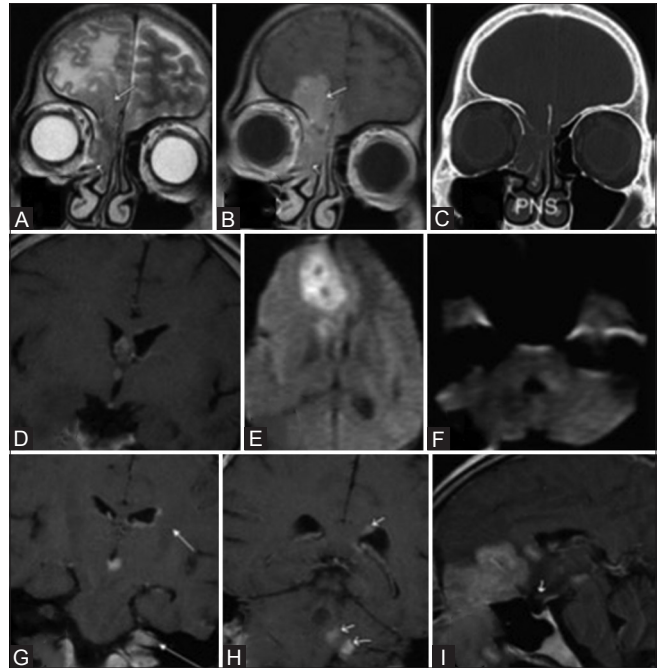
(A-H): History – A 26-year-old immunocompetent male presented with headache with vomiting for 6 months; double vision and blurring of left eye; hearing loss in left ear for about 3 months; foul smelling discharge from nose for 1 month. On MRI, there was a lesion hypointense on T2 W (A) images, homogeneously enhancing with contrast as seen on post-contrast T1 image (B) involving the right nasal cavity, posterior ethmoid air cells (small arrows) with intracranial extension (large arrows). CT PNS (C) showed a soft tissue density mass in the same location with bony erosion and intracranial extension. Post-contrast T1 W images (D and G-I) showed subependymal enhancement of left lateral ventricle (small arrow in G), enhancement of seventh/ eighth cranial nerve complex (large arrow in G), periventricular enhancing nodules along third ventricle, enhancing lesions in cerebellar vermis (arrows in H) and hypothalamic location (arrow in I). All the lesions showed diffusion restriction on diffusion weighted images (E and F) [and apparent diffusion coefficient images (ADC) images not shown in the figure]
